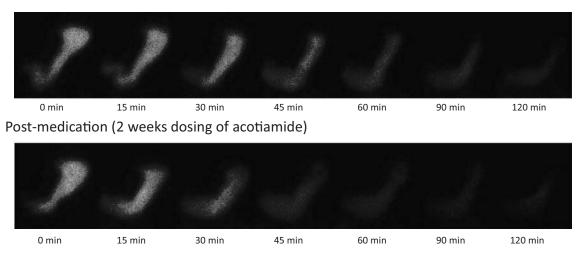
Effect of acotiamide on gastric motility using gastric scintigraphy. Representative images of the gastric scintigraphy of Japanese FD patients of pre and post medication of acotiamide. The gastric radioactivity was apparently increased after 2 weeks of dosing of acotiamide, suggesting
